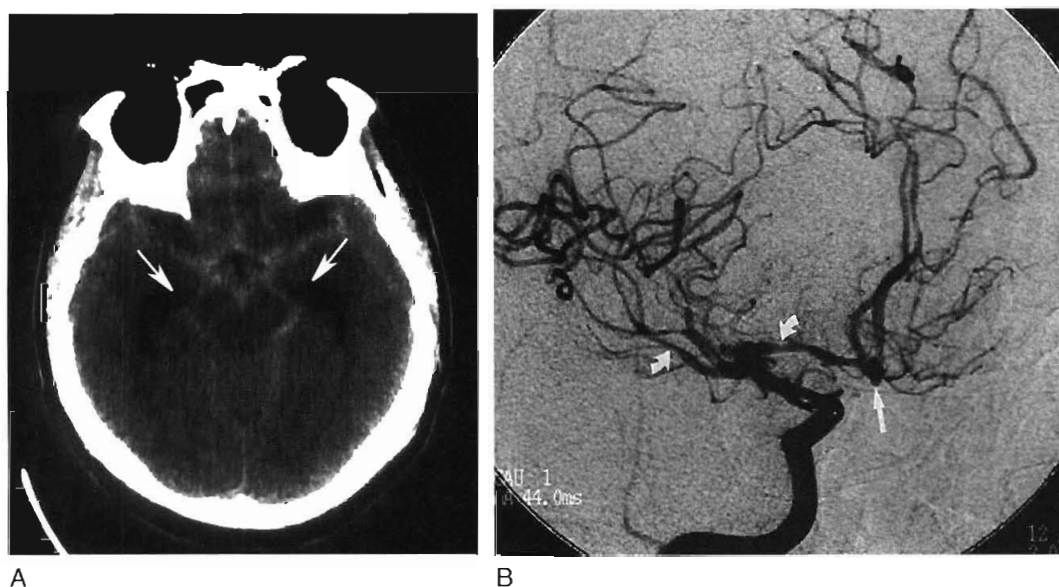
Subarachnoid hemorrhage and aneurysm. *A*, Axial non-contrast-enhanced CT scan of the head reveals high density (blood) replacing the normal low density of cerebrospinal fluid within the suprasellar cistern and subarachnoid spaces. This indicates subarachnoid hemorrhage. Note also the dilated temporal horns (*arrows*), indicating acute hydrocephalus. *B*, Right internal carotid artery angiogram demonstrates the presence of a congenital anterior communicating artery aneurysm (*arrow*), as well as vasospasm (*curved arrows*).
